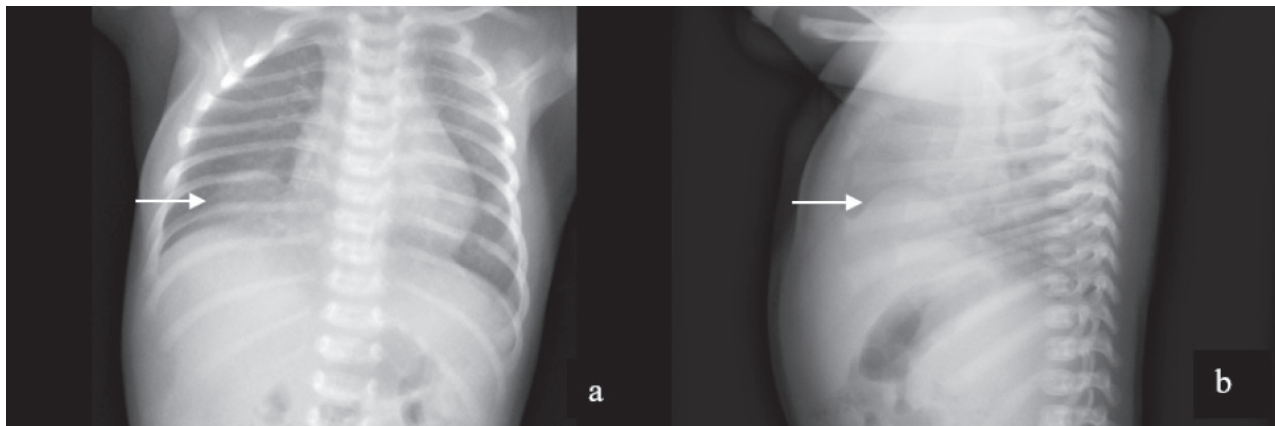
Chest radiograph, frontal (a) and lateral (b) projections, shows elevated right hemidiaphragm.
